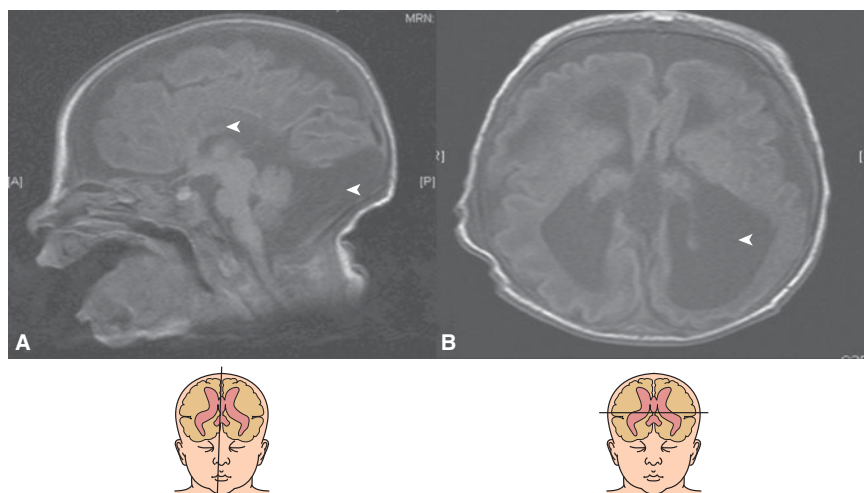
MRI T1-weighted images of the same infant as in Figure 12-2 on day 1 of life. (A) Median section confirms callosal and posterior fossa abnormalities (*arrowheads*) with large extra-axial spaces due to a reduction in brain mass. (B) Axial section shows bilateral ventriculomegaly (*arrowhead*). Note the presence of diffuse white matter abnormalities and pachygyria.
